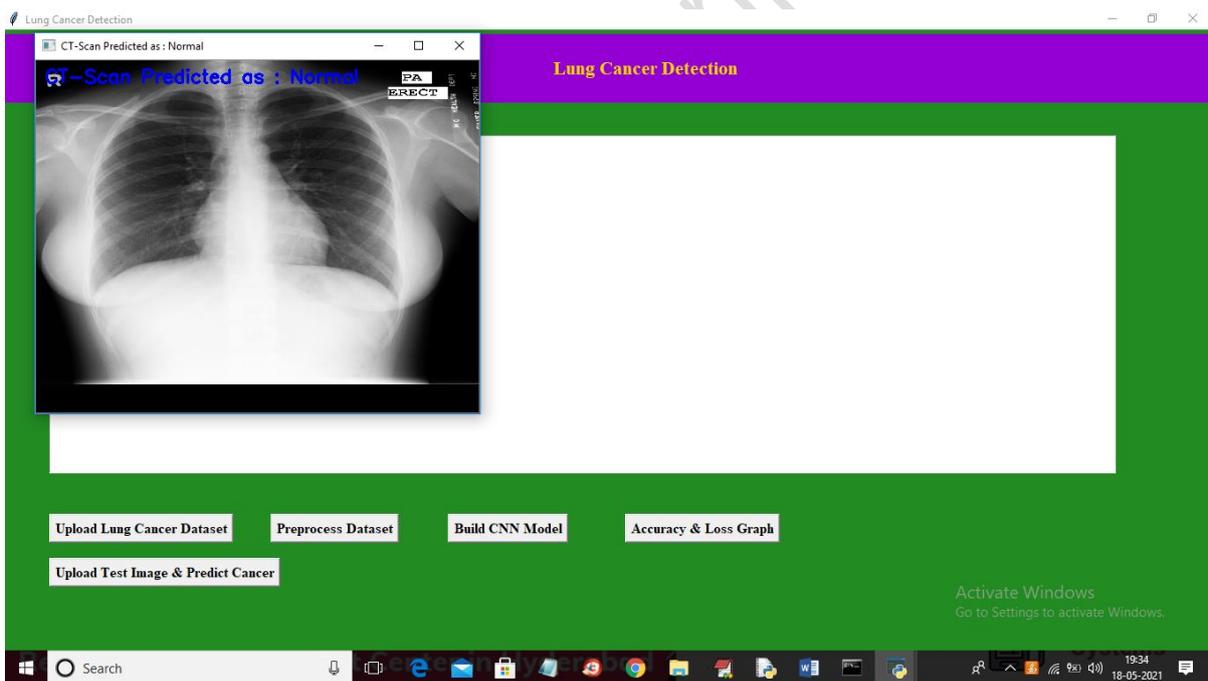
In above screen CT-SCAN is predicted as NORMAL. Similarly you can upload and test other images
